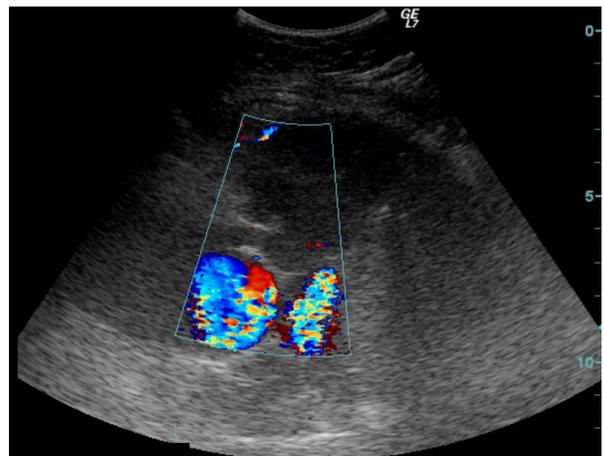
A hypoechoic mass lesion measuring 6x5 cm with irregular contours is seen on thoracic ultrasound in the anterior mediastinal region from the parasternal approach, as well as the color Doppler flow in the vascular structures adjacent to the lesion.
